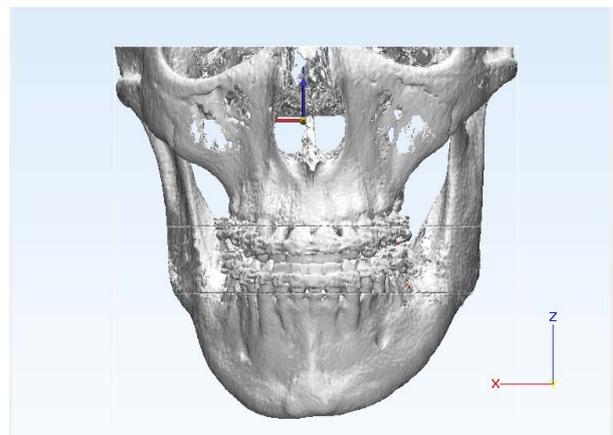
Three-dimensional skull model used in the pre-operative planning created from computed tomography (CT) data.
